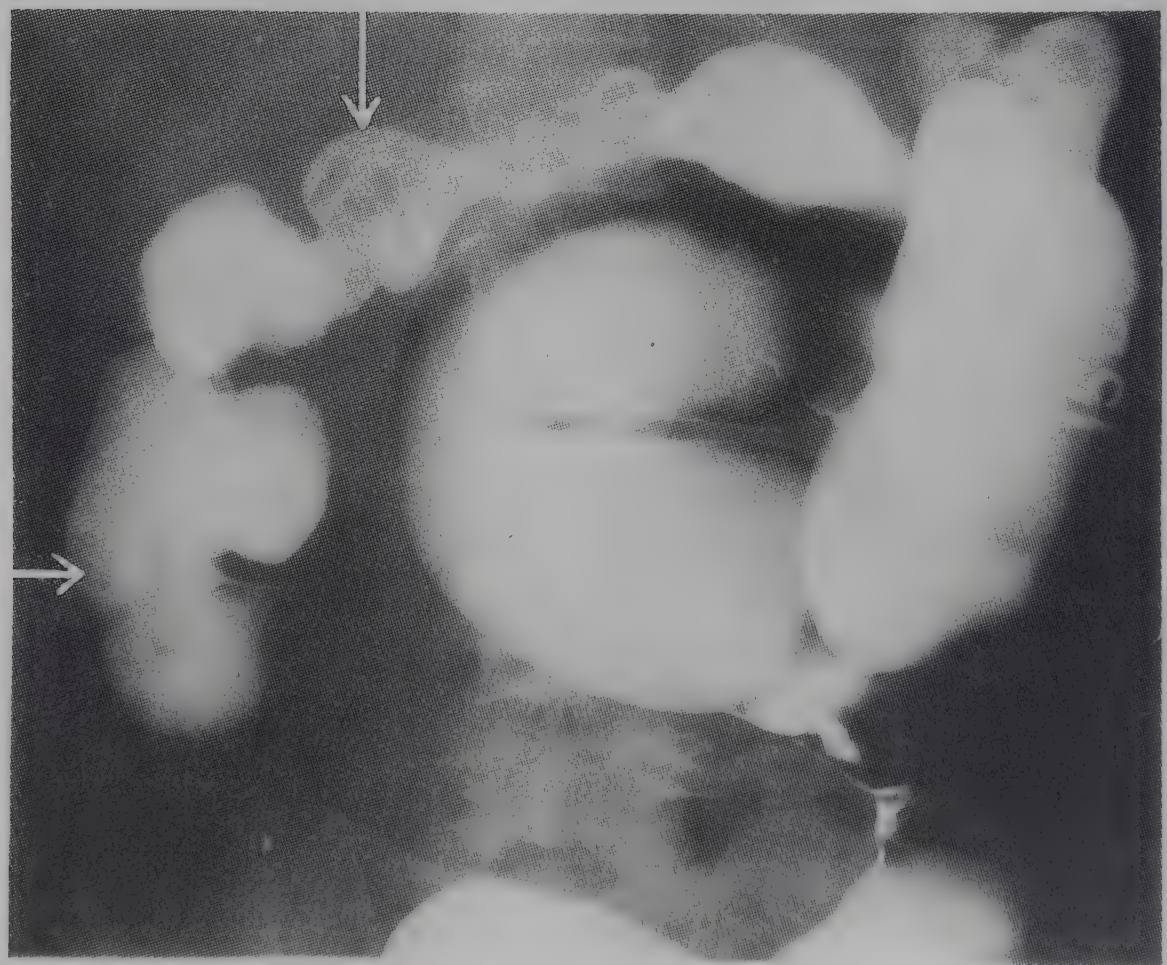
Abdominal x-ray barium enema of the same patient.
